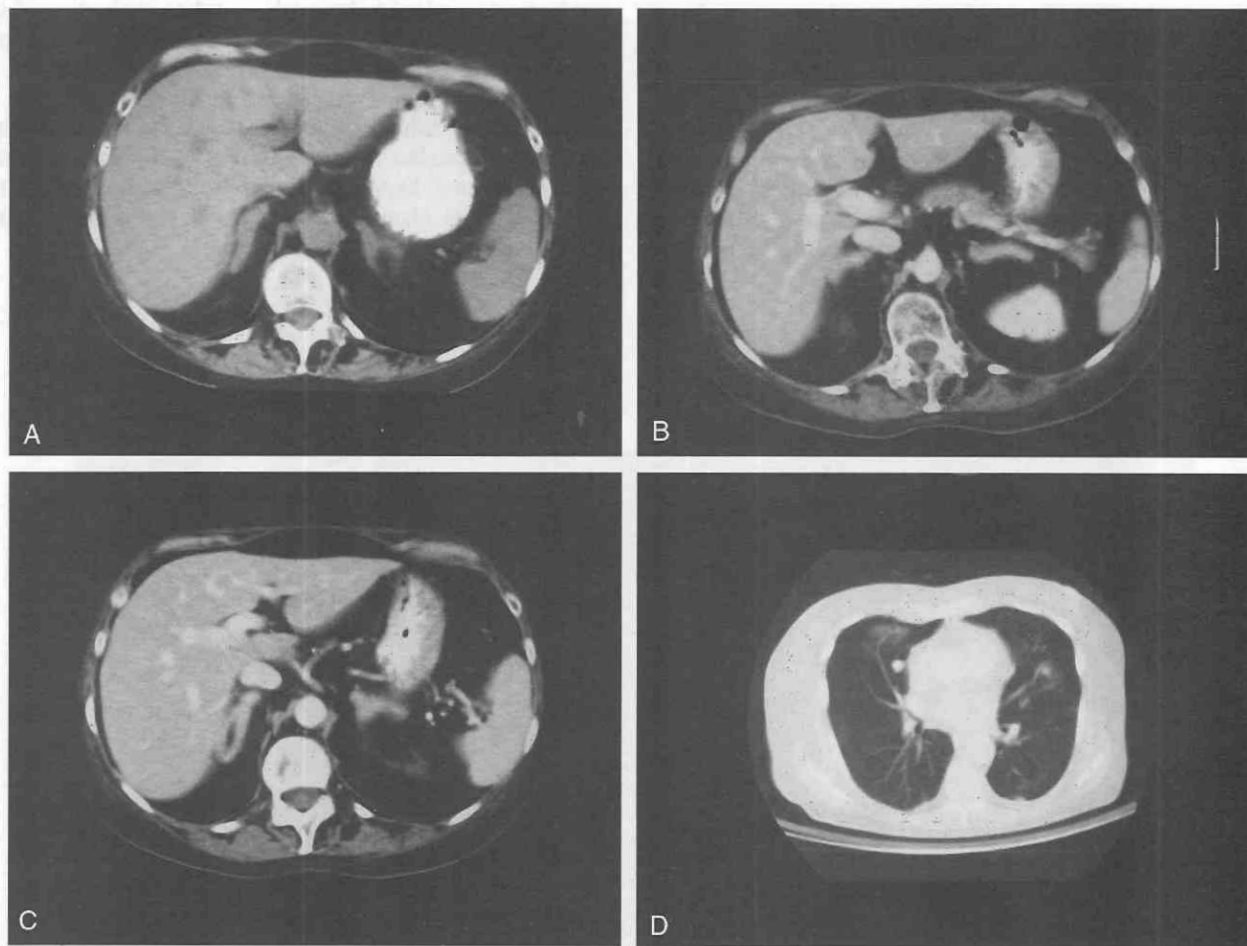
Cushing's syndrome. *A-C*, Non-contrast-enhanced and contrast-enhanced CT scans of the adrenal glands reveal symmetrical hypertrophy. *D*, CT scan of the chest demonstrates a 1-cm nodule in the right middle lung. The nodule was a bronchial carcinoid ectopically secreting adrenocorticotrophic hormone, which resulted in Cushing's syndrome. (Courtesy of Mayo Foundation.)
